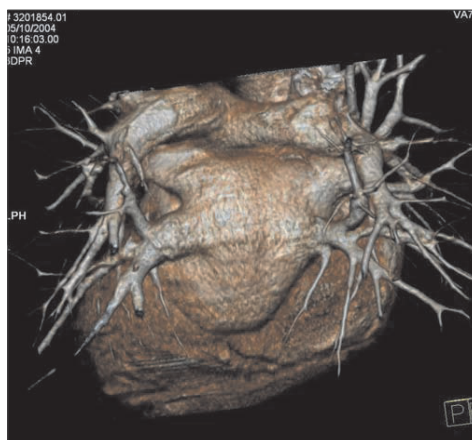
3D reconstruction multislice CT scan. Posterior view. The tube-shaped portion of the pulmonary veins becomes funnel-shaped before entering the left atrium.
